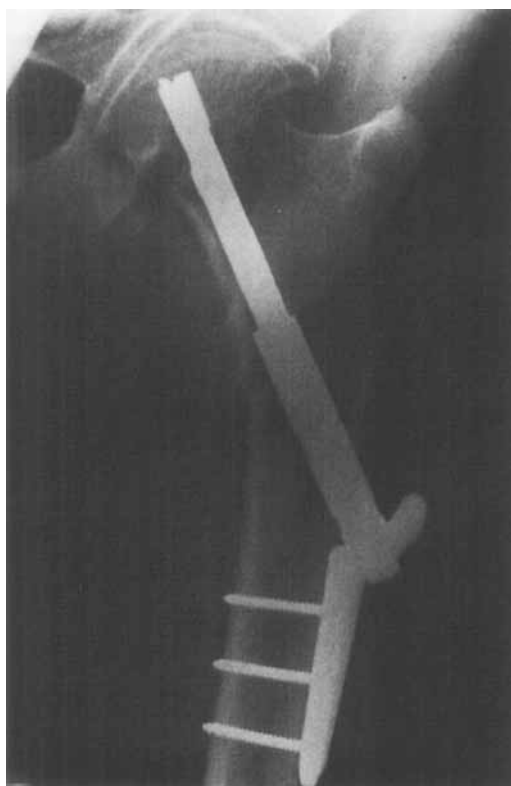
Radiograph of the sliding-nail-plate in a femoral neck fracture.
